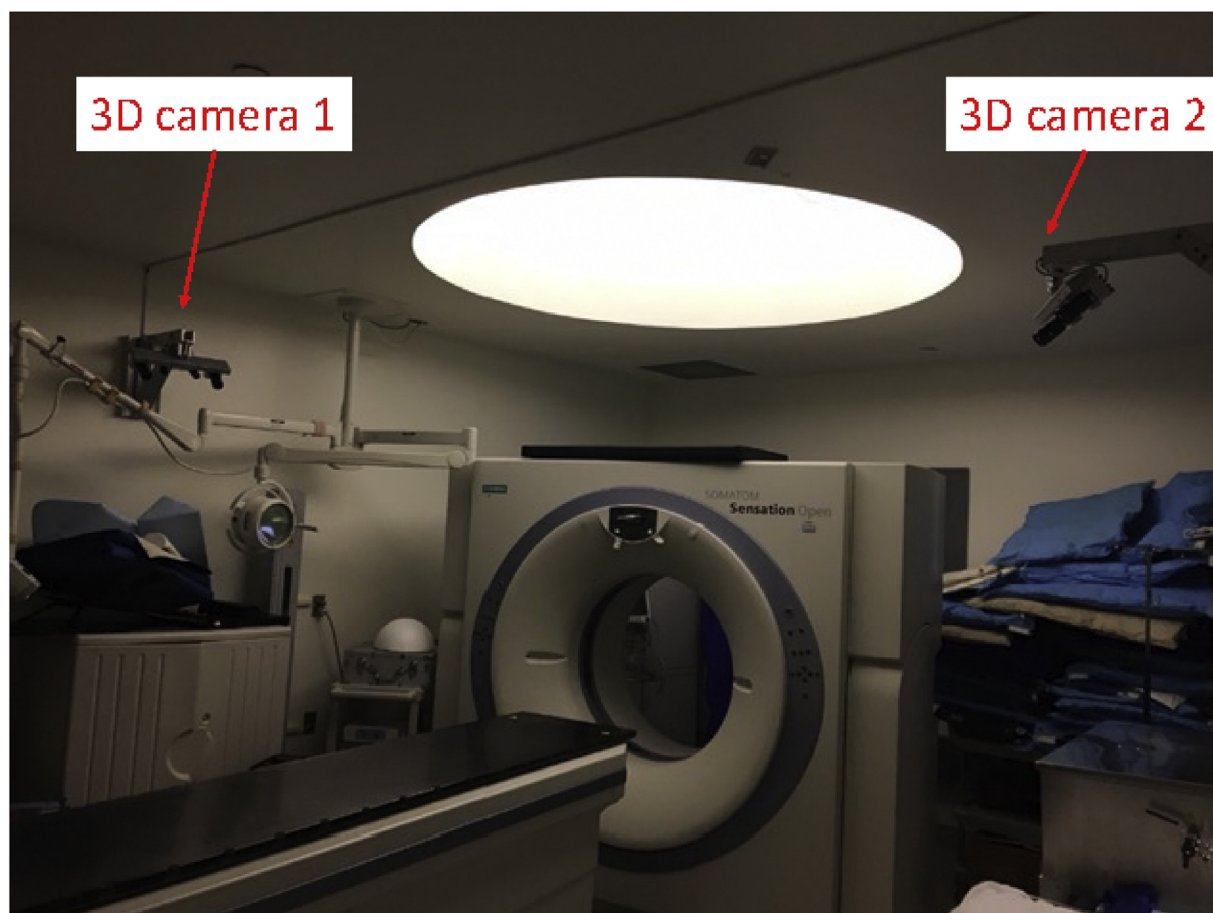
A pair of experimental wide-angle 3-dimensional cameras mounted on both sides of the computed tomography couch capture the entire patient length.
